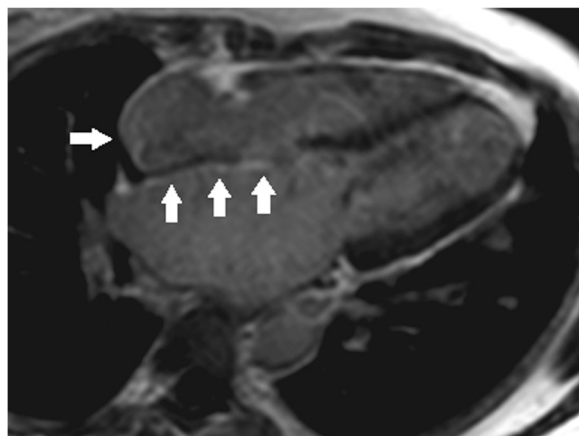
DE-MRI showing LA enlargement and moderate atrial fibrosis (involves the entire septum and the right atrium, arrows)
